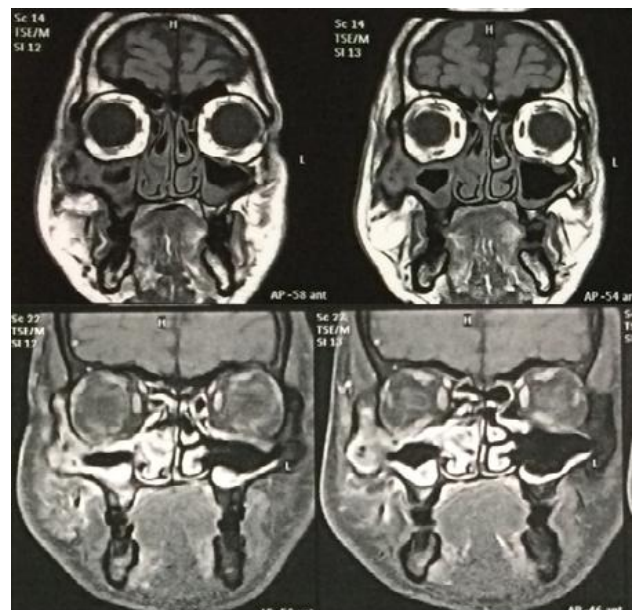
Pre and post contrast MRI T1W showing lesion involving right maxillary sinus.
